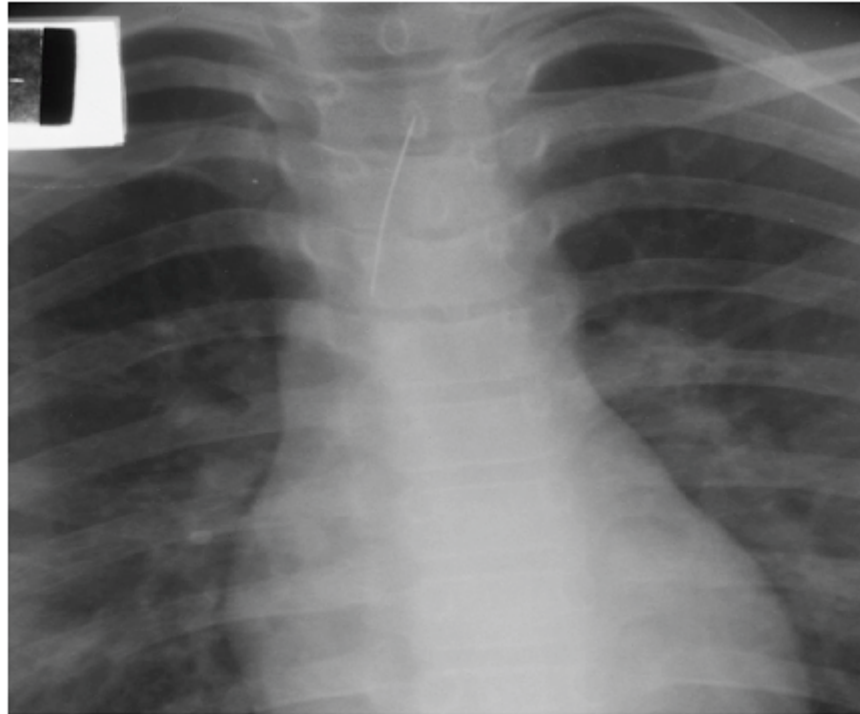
Second Chest Radiograph Taken Showing the Previous Radio-opaque FB had Migrated to the Trachea
